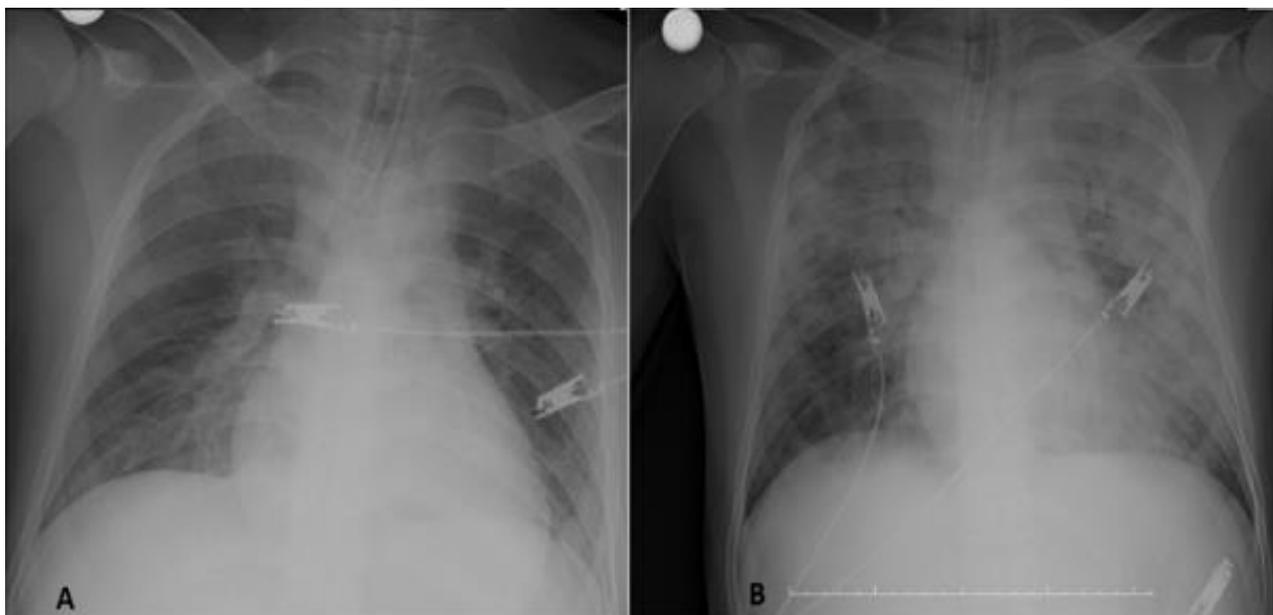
Chest X-ray of the patient on ICU admission (A) and in following hours of treatment (B) Increased patchy
